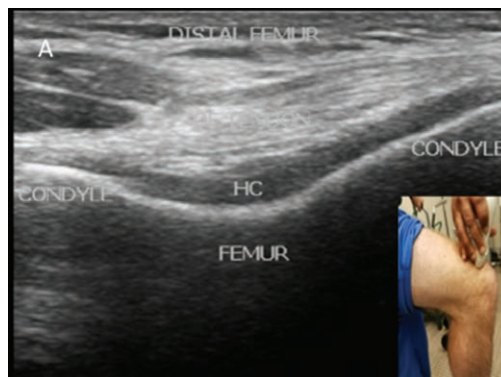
Ultrasound image of the knee in 90° of flexion at distal femur. HC = hyaline cartilage.
